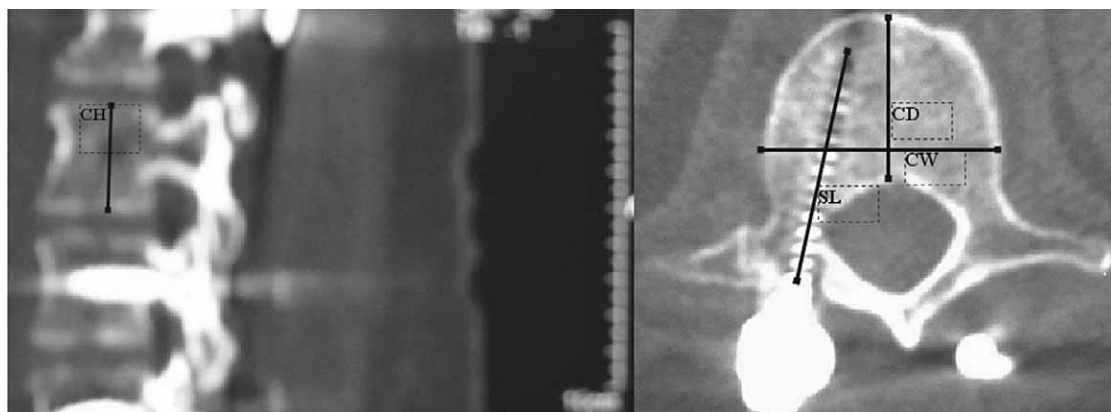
Transversal and sagittal CT scans with vertebral body dimensions – CW, CH, CD and clearly visible transpedicular screws.
